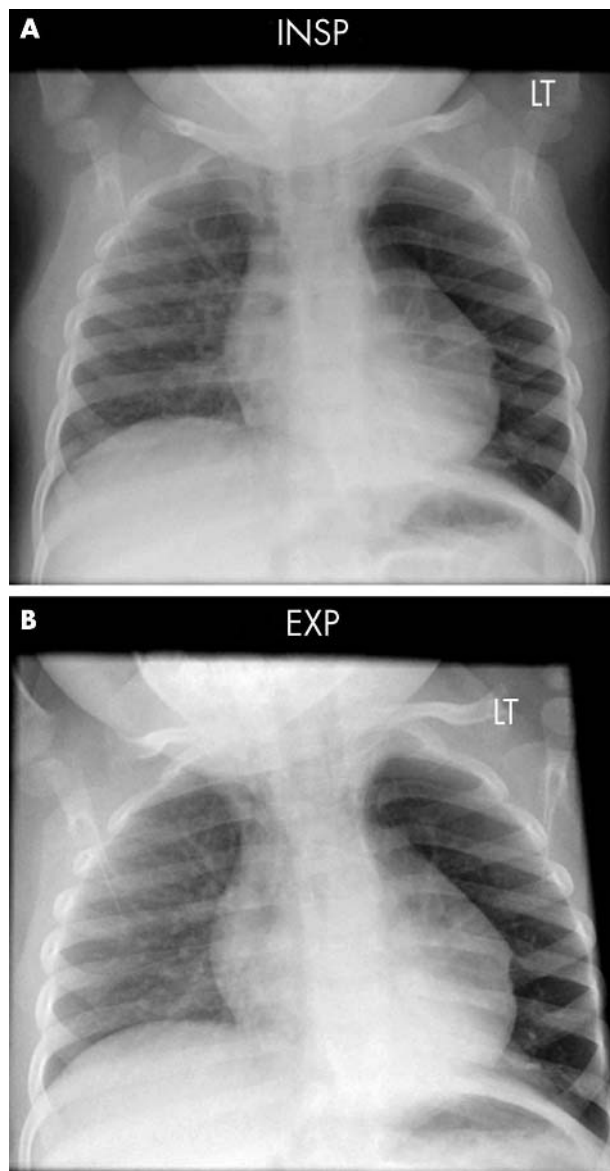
Case 2: inspiratory and expiratory chest radiographs.
